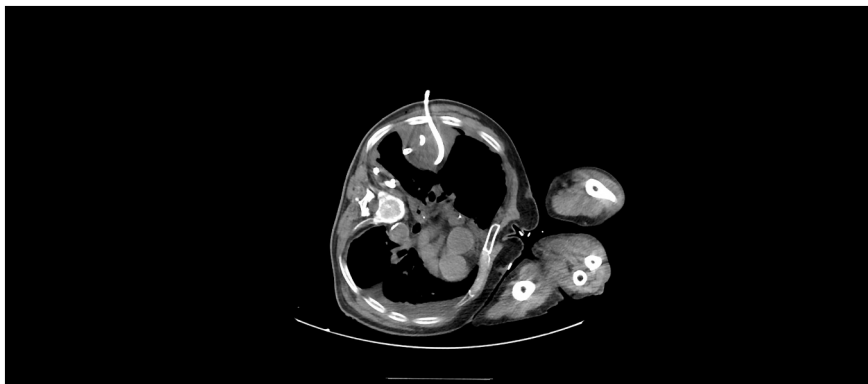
CT - empyema cavity of the right lung – CT-guided drainage.
